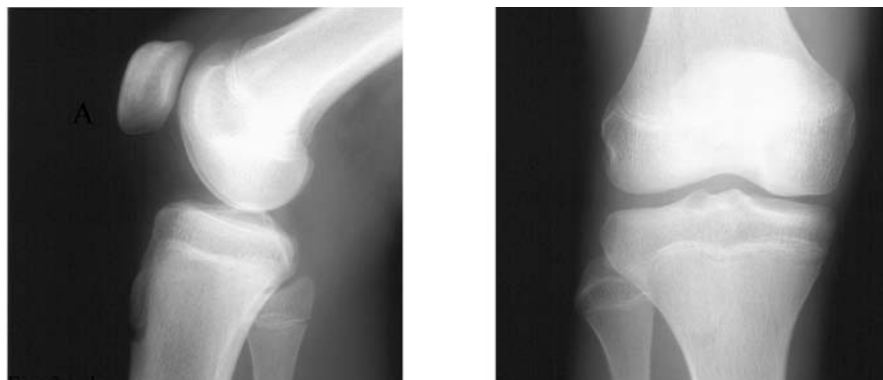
x-ray of a right knee (anterior-posterior and lateral)
